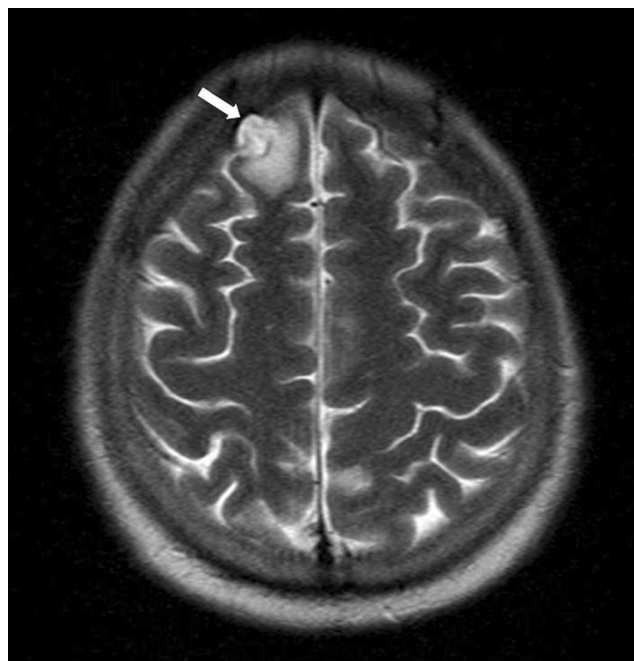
Axial T2-weighted MRI showing hyperintense frontal metastasis
